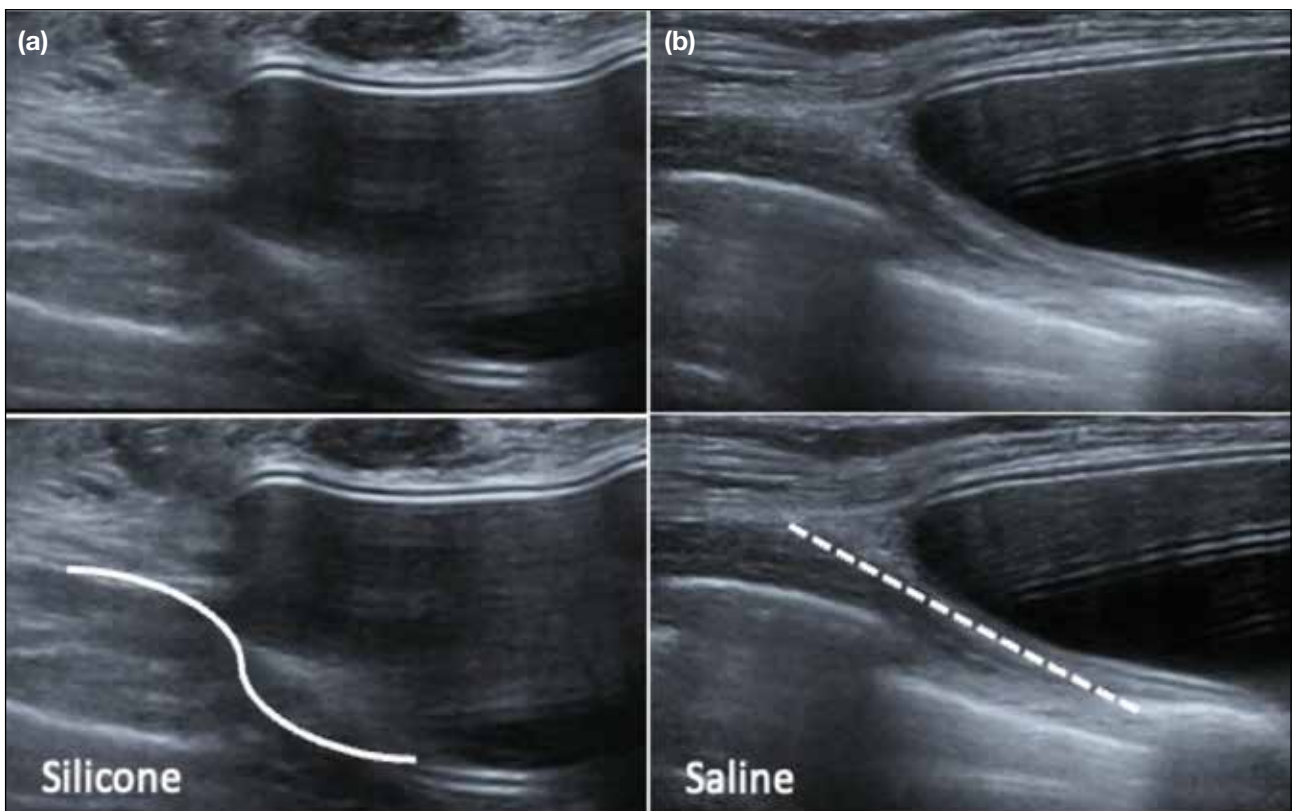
Ultrasonographic appearance of silicone and saline implants. (a) In the case of silicone implant, the chest wall behind the implant may appear 'deeper' due to the slower transmission speed of ultrasound waves through silicone compared to the expected location of the chest wall. This creates a 'stepped' appearance on the ultrasound image (solid line). (b) In contrast, saline implants typically appear as anechoic structures surrounded by a linear echogenic envelope, and the chest wall appears smooth on ultrasonography (dashed line).
